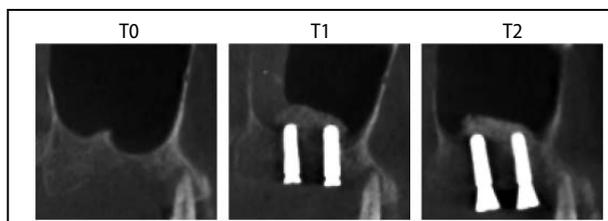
Representative sagittal CBCT slices showing a case of membrane perforation. An air-fluid level (*) was visualized in the affected sinus at T1. At 6 months (T2), the fluid level was not present, and the sinus was clear.
